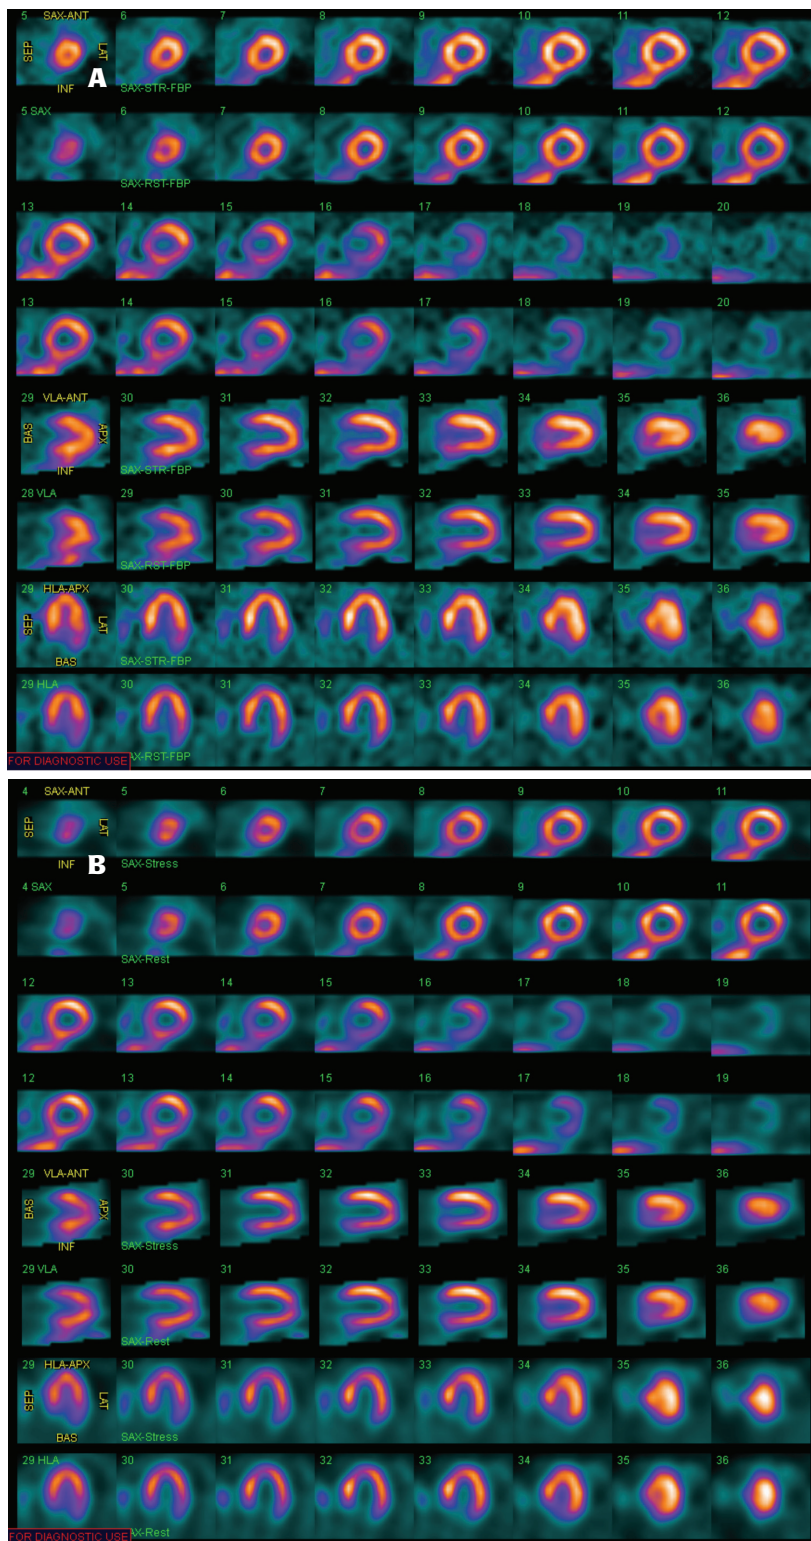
SPECT/CT images show full-time data without Astonish (A) versus half-time data with Astonish (B). Both studies were reported as normal.
